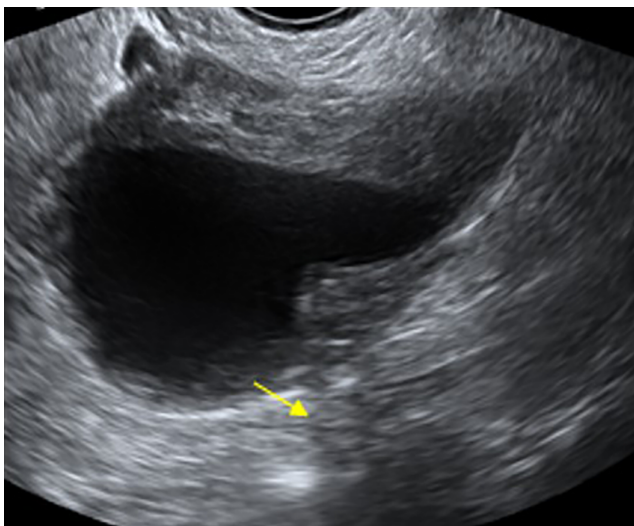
Grayscale ultrasound image of unilocular solid serous cystadenofibroma with solid component and papillary projection in 38-year-old woman. Shadowing (arrow) is seen.
